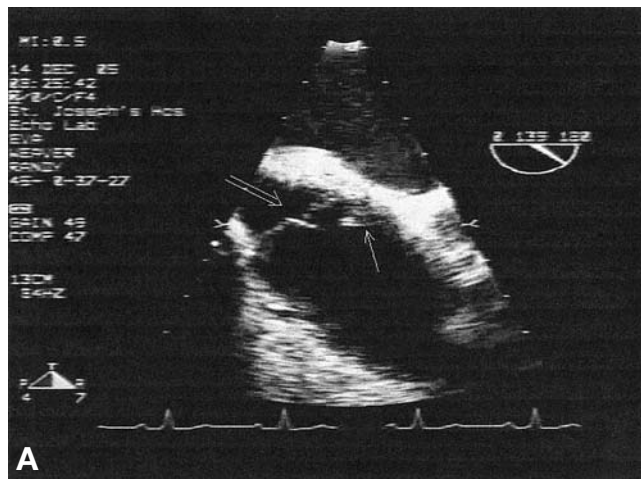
a) Long-axis view of aortic homograft on transesophageal echocardiogram showing prolapse and failure of coaptation of two leaflets (double arrow), with the third leaflet appearing immobile and retracted (single arrow). b) Color Doppler view showing eccentric jet compatible with severe aortic regurgitation.
